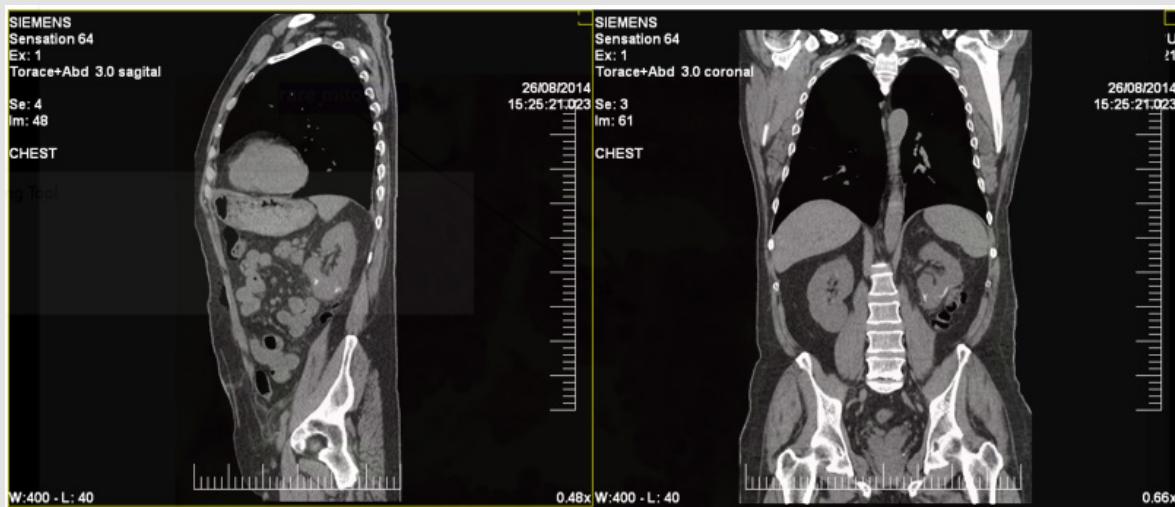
Sagittal and coronal views of a CT scan demonstrating a solid renal mass at the lower pole of the left kidney, measuring approximately 37 x 35 x 31 mm. (2014).
